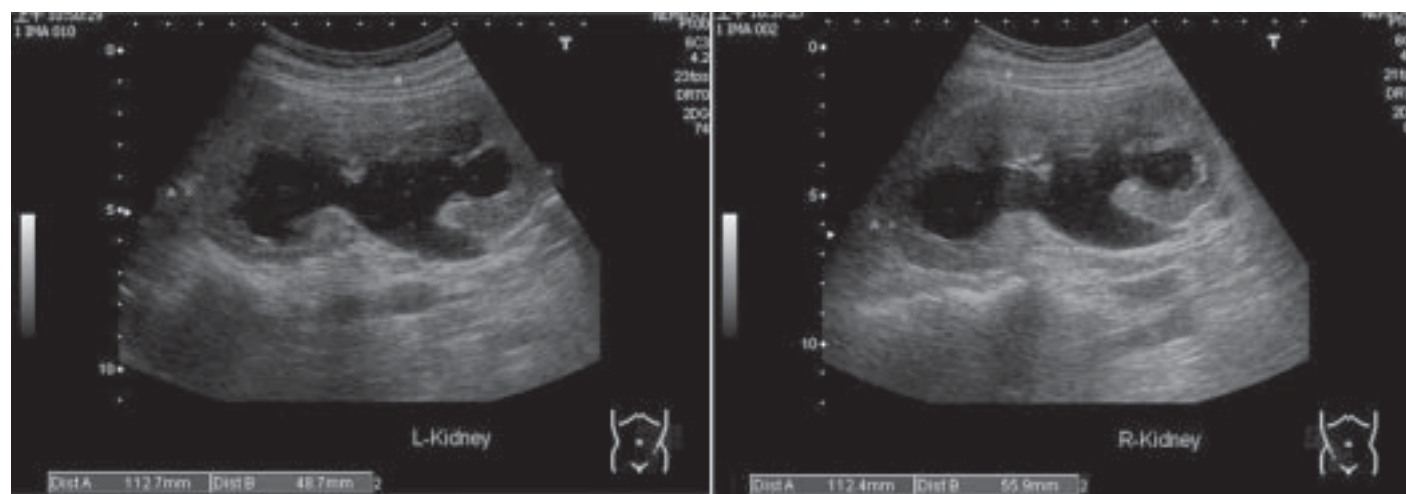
Renal sonography showing obstructive hydronephrosis in both kidneys.
